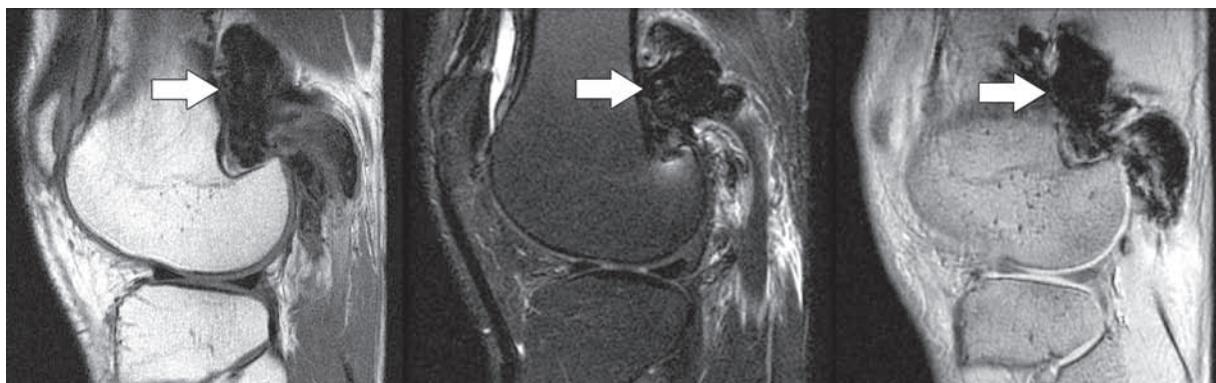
PVNS. T1-weighted (left) and T2-weighted fat-saturated (middle) MR images show a low-signal-intensity mass (arrow) in the knee. Right: On a gradient-echo image, the mass (arrow) demonstrates blooming artifact, which is due to the presence of hemosiderin and is a characteristic feature of PVNS.
